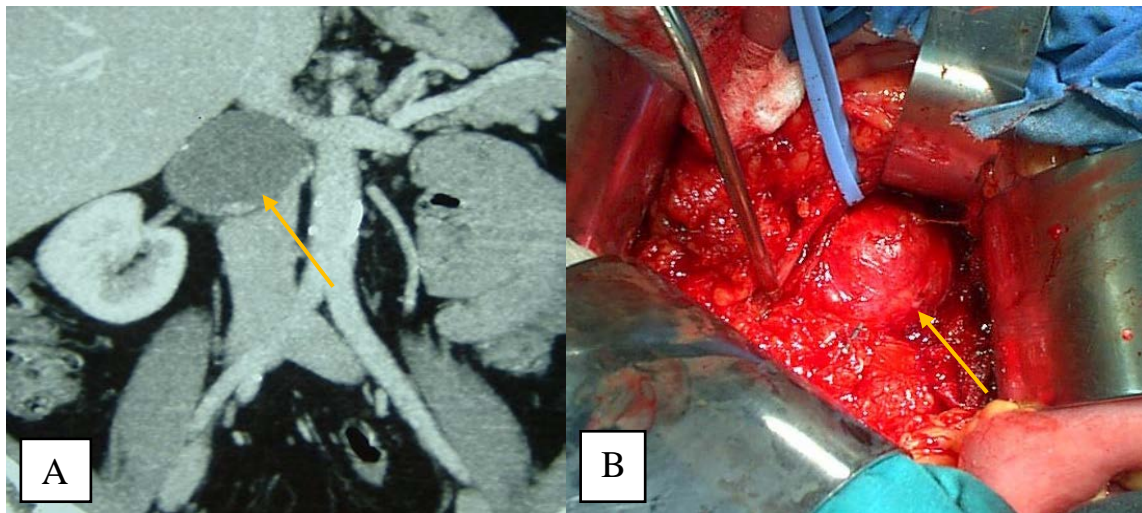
Aneurysm of superior mesenteric artery (SMA): A) multi-detector computed tomography angiography shows an aneurysmal dilatation of SMA, and B) intraoperative photograph of SMA after surgical exposure – the aneurysmal segment identified on preoperative imaging.
